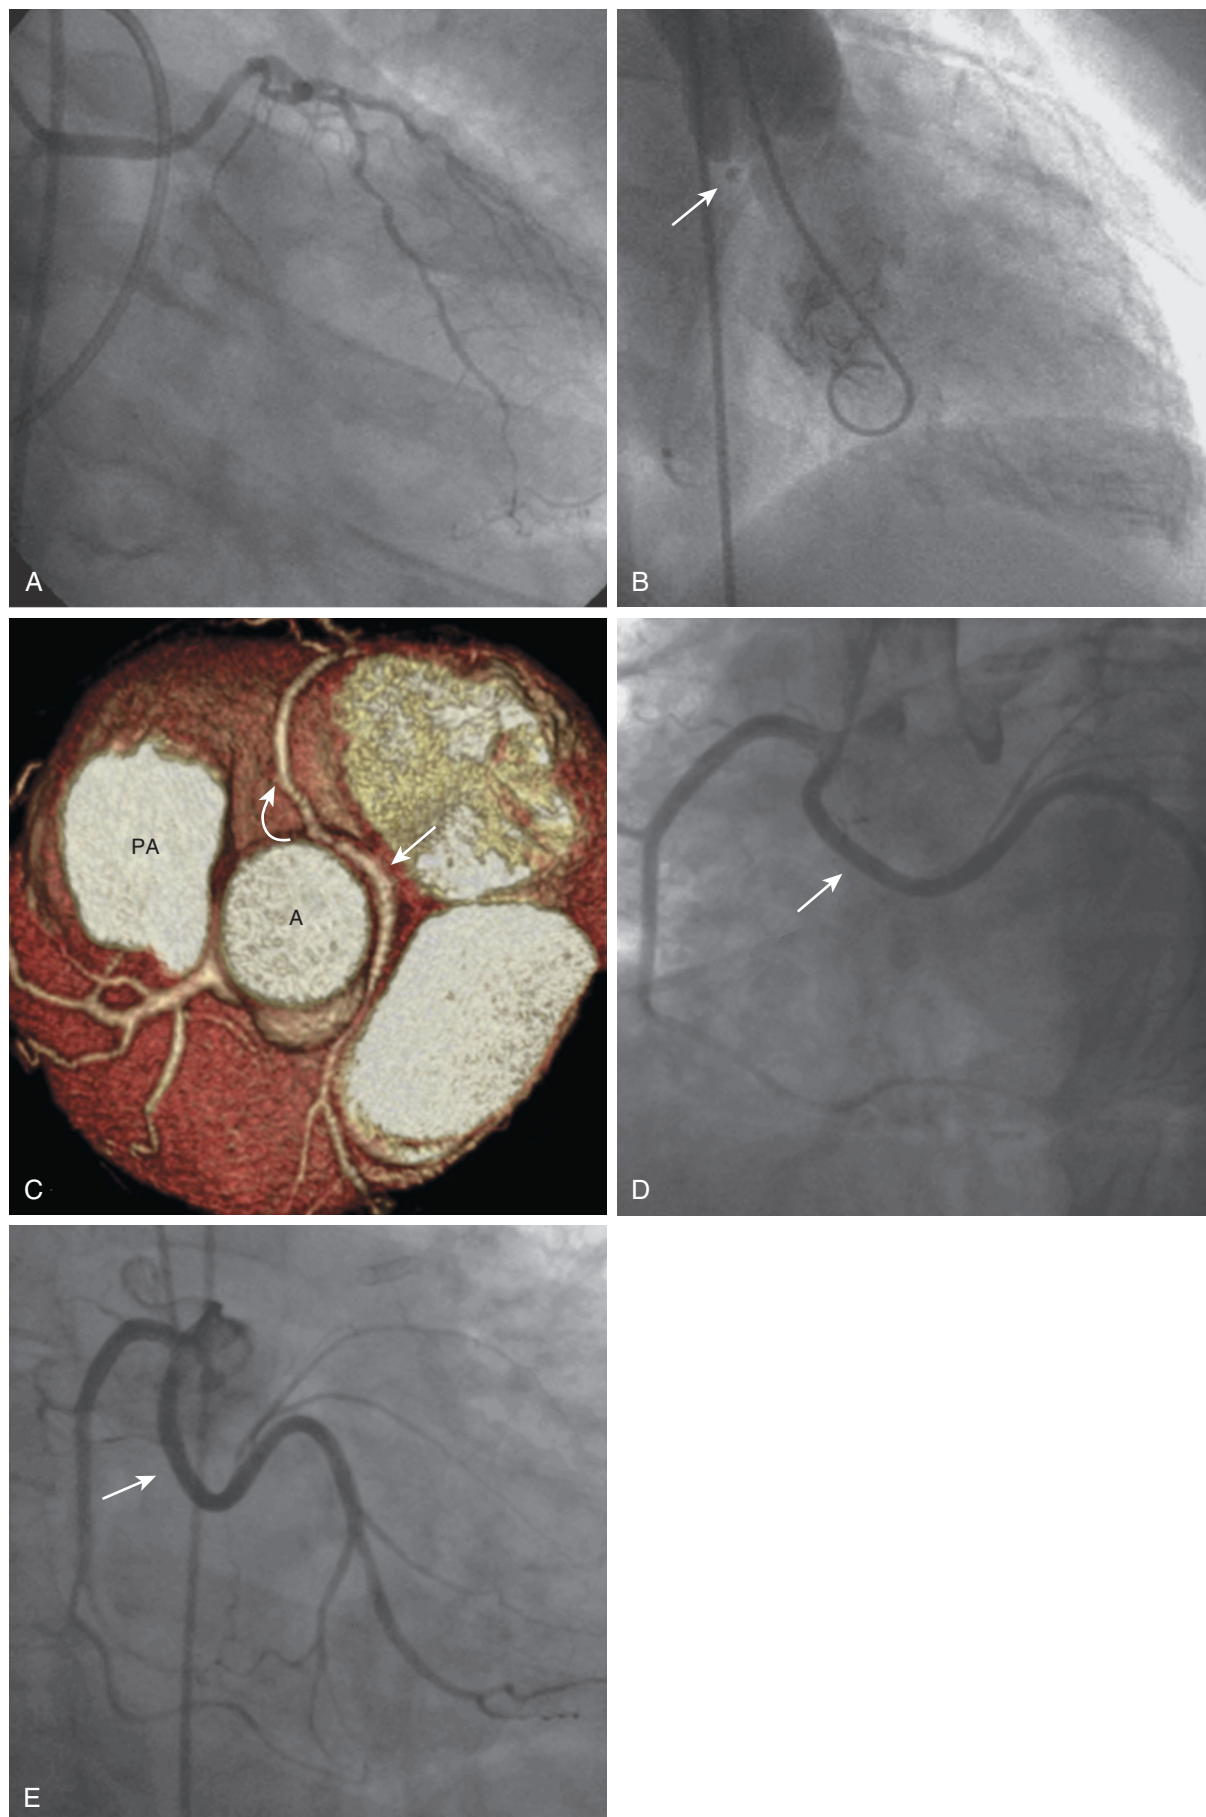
Anomalous origin of the LCx artery from the right coronary sinus. A, The LAD artery arises from the left coronary sinus in the usual location, but the LCx artery is absent. B, A left ventriculogram in the RAO projection shows the “button sign” (*arrow*) of the anomalous LCx artery coursing behind the aorta. C, Computed tomography angiography image shows the origin of the LCx artery from the right coronary sinus and passing behind the aorta (*A*, *arrow*). D, E, Angiographic demonstration of the anomalous LCx artery (*arrows*) from the right coronary sinus shown in the LAO (D) and the RAO (E) projections. PA = pulmonary artery.
